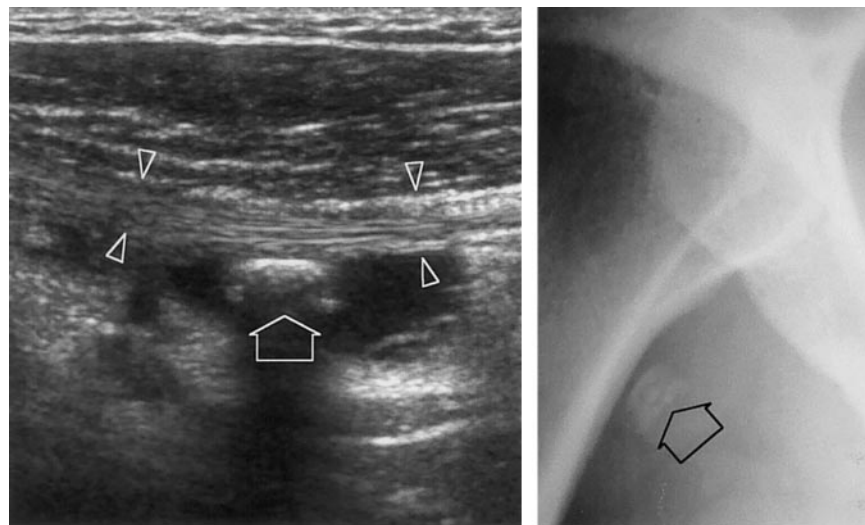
Intraarticular loose body in a 45-year-old woman. (a) Longitudinal 12–5-MHz US image of the shoulder obtained at the level of the sheath of the LBT (arrowheads) demonstrates a loose body (arrow) surrounded by anechoic fluid in the synovial space. (b) Corresponding radiograph shows the fragment with a typical laminated concentric appearance (arrow).
